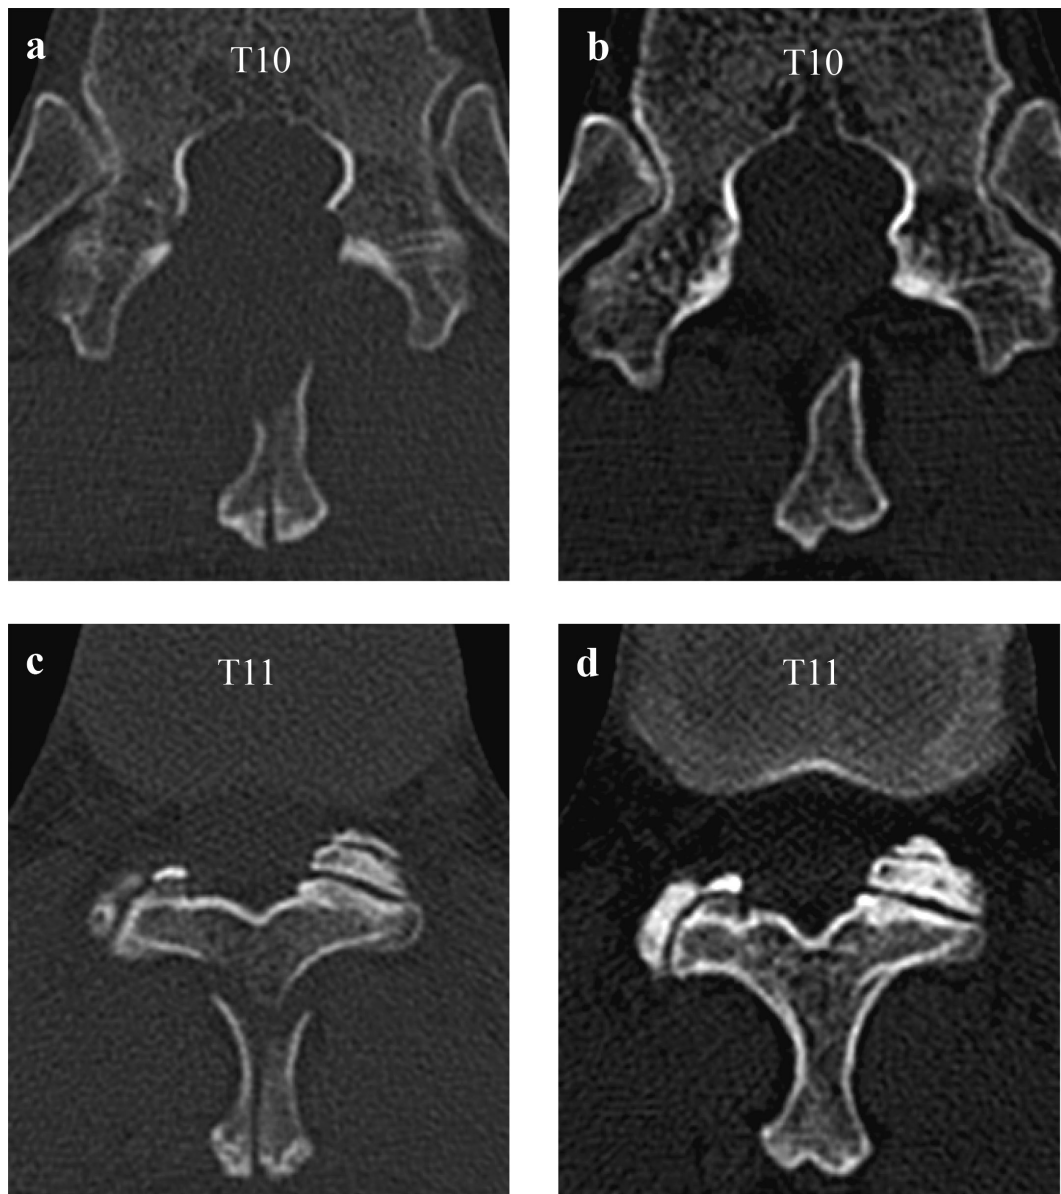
Axial computed tomography findings of Case 2 at 1 week (a, c) and 1 year after surgery. Split spinous processes of T10 have fused together (b) 1 year after surgery. The spinous process of T11 is fused at the lamina 1 year after surgery (d).
